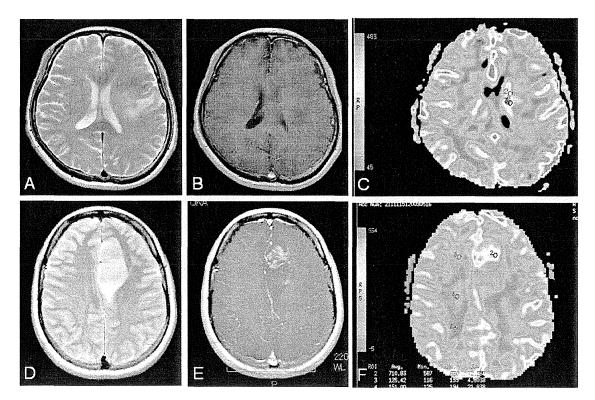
(A–C) A representative case of an oligoastrocytoma. (A) Axial transverse T2-weighted image shows a left frontal tumor. (B) Axial contrast-enhanced transverse T1-weighted image shows the tumor with partial enhancement. (C) The rCBV map shows that the rCBVmax value of the tumor is 5.72. (D–F) A representative case of an anaplastic oligoastrocytoma. (D) Axial transverse T2-weighted image shows a left frontal tumor. (E) Axial contrast-enhanced transverse T1-weighted image shows the tumor with partial enhancement. (F) The rCBV map shows that the rCBVmax value of the tumor is 6.23.
